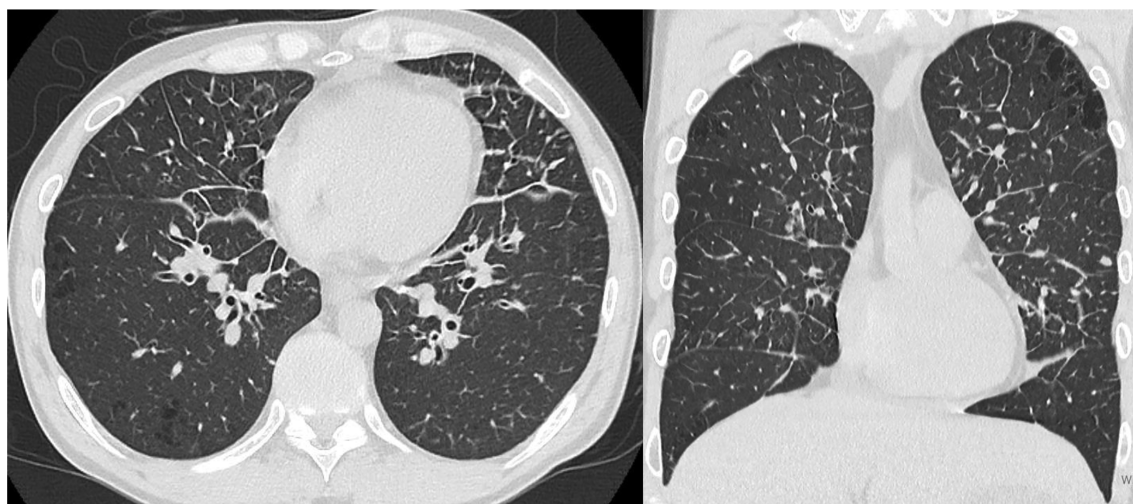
Chest computed tomography showing bilateral ventral-predominant interlobular septal thickening.
